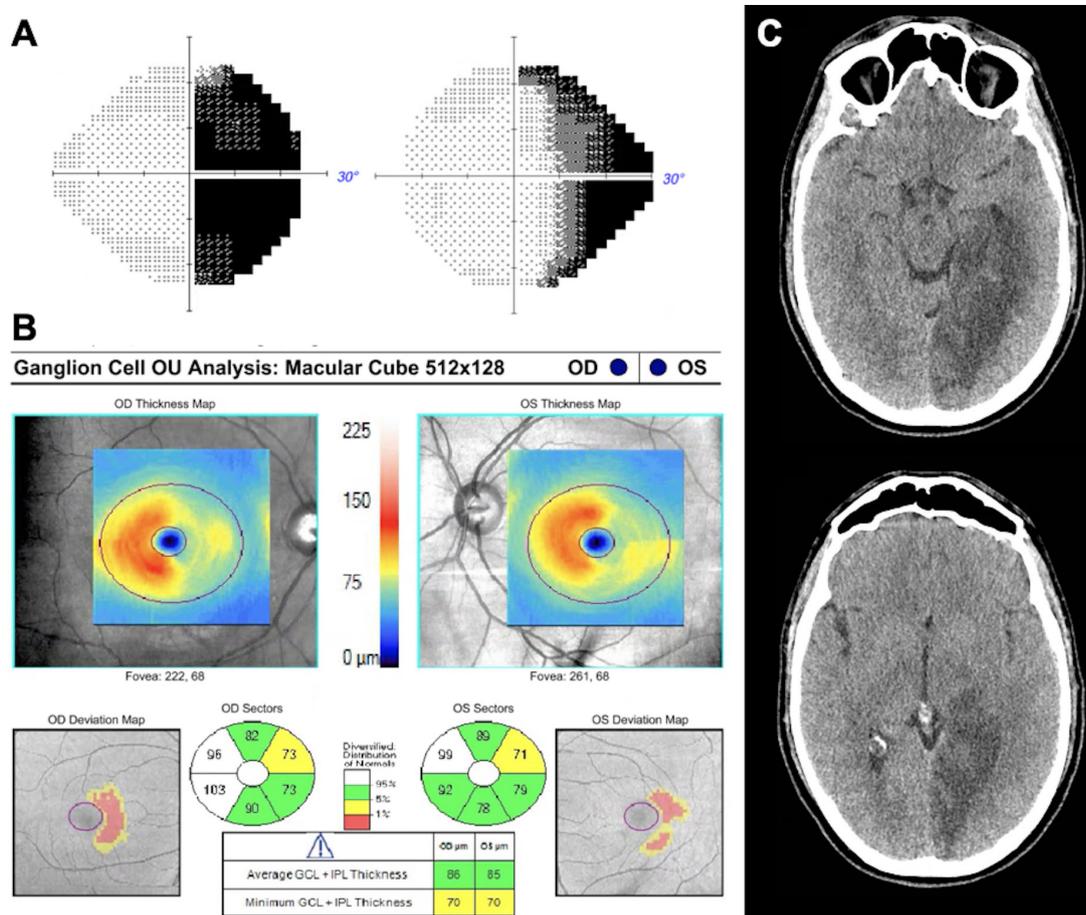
(A) Humphrey 24-2 SITA-FAST visual field testing revealed right homonymous hemianopia. (B) Optical coherence tomography demonstrates left homonymous hemi-macular atrophy of the ganglion cell–inner plexiform layer. (C) CT of the head showed early ischaemic changes involving the left medial temporal lobe, occipital lobe and thalamus.
